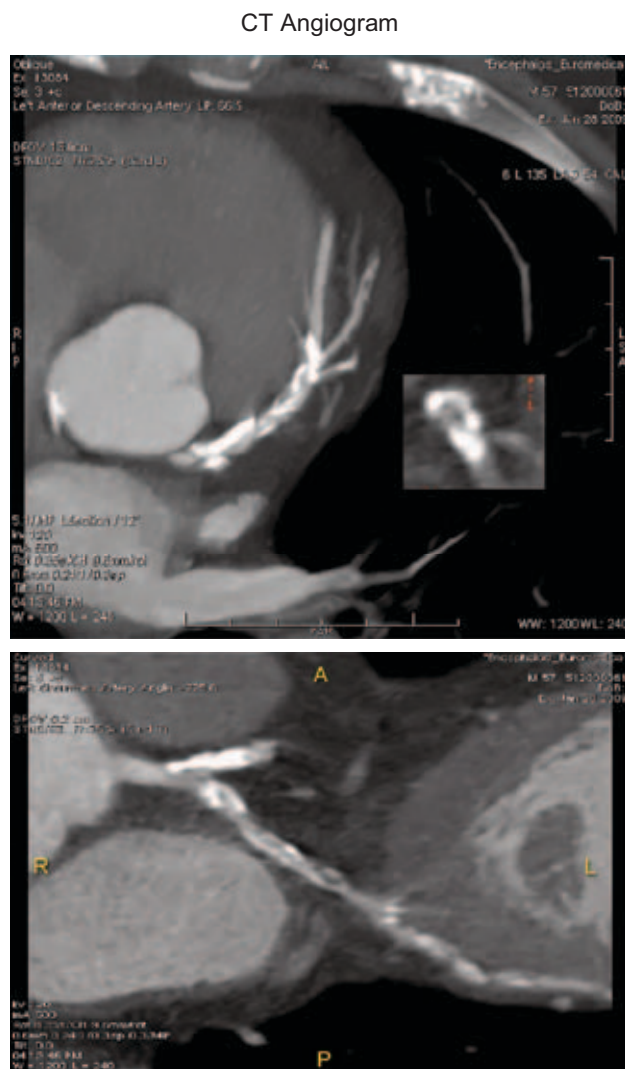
SPECT^{99m}Tc-tetrofosmin myocardial perfusion and CT coronary angiography images in a patient with suspected coronary artery disease. Rest and stress myocardial perfusion SPECT images are essentially normal. The coronary anatomy was left-dominant (images not shown). The CT angiogram demonstrates extensive calcification of the dominant left coronary artery, with a short segment of heavily calcified plaque in the distal left main coronary artery. The inset shown in the panel on the upper left is a cross section through the left main coronary artery, suggesting moderate calcified luminal stenosis.
